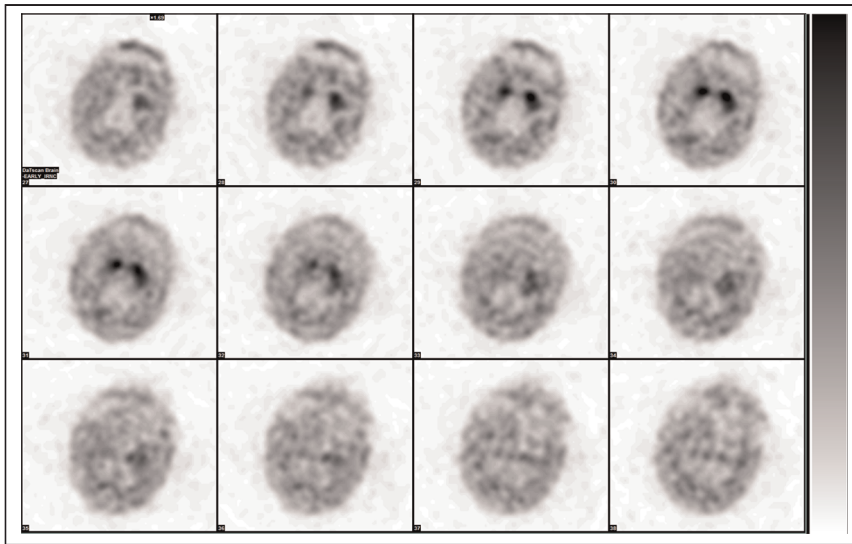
Axial brain SPECT images of 87-y-old woman with parkinsonian features, left-sided weakness, dysarthria, and generalized weakness. Images show head tilt, normal comma shape on left, decreased uptake in right putamen, and dilated ventricles.
